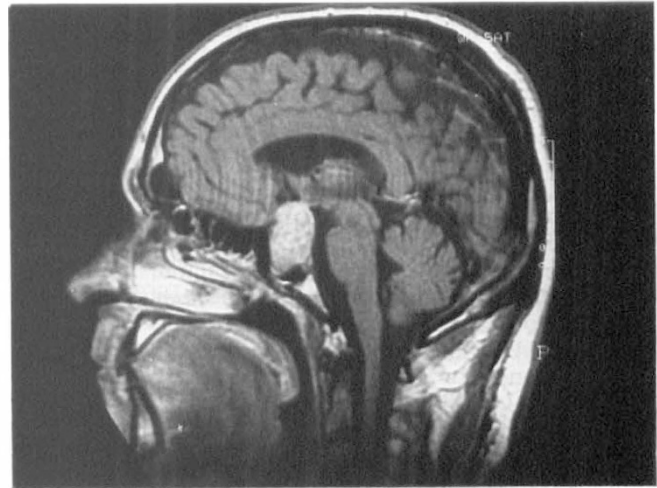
T1-weighted sagittal MRI scan with gadolinium contrast. There is a large pituitary mass taking up contrast.
